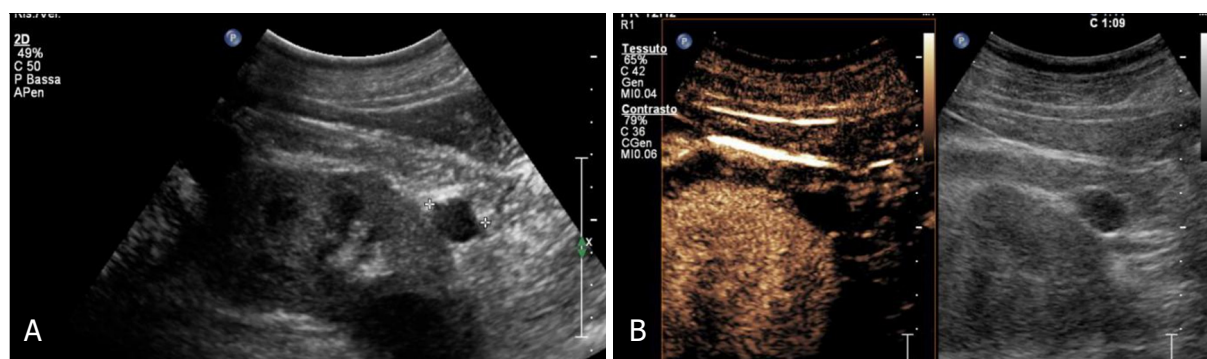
Bosniak 2 cyst. A: Grey scale and contrast enhanced sonograms shows small exophytic hypoechoic mass with smooth margin in lower pole; B: Completely avascular after microbubble injection
